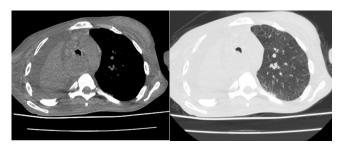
Atelectasis in the right lung and dilatation of the esophagus seen on Thorax CT
